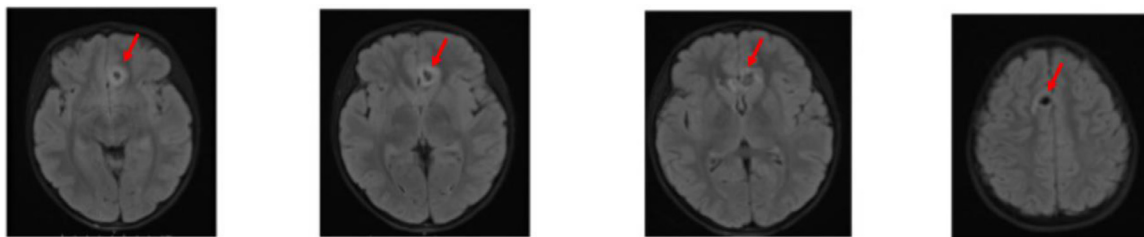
Magnetic resonance imaging (MRI) of the brain without contrast with T2 fluid attenuated inversion recovery (FLAIR) sequence showing findings consistent with the previously acquired CT with retained bullet fragments, blood, and acute penetrating injury from the gunshot wound entering the left anterior maxillary alveolar process and coursing superiorly into the brain parenchyma involving the left and right medial frontal lobes. The bullet track is highlighted by the red arrows.
